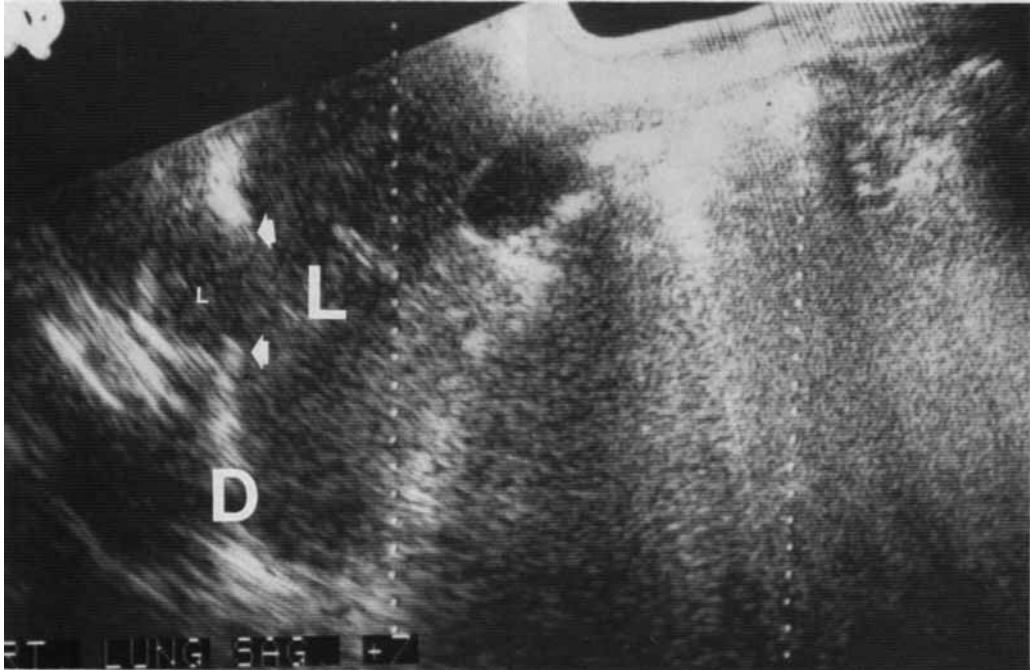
Case 1*: Longitudinal ultrasound scan through the right upper quadrant of the abdomen showing a defect (arrows) in the diaphragm with liver tissue protruding into the thorax. L = Liver, D = Diaphragm.
